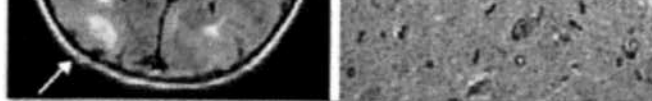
Brain lesions in tuberous sclerosis. A. Brain MRI of an 8-year-old boy using the FLAIR technique demonstrates several cortical tubers (white, cortical lesions, indicated by arrows) and subependymal nodules lining the ventricles (arrowheads). Courtesy of J. Egelhoff, Cincinnati, OH. B. High power view of a cortical tuber shows giant cells (white diamonds). Cortical surface is to the right. Courtesy of J. Chan, Boston, MA.
